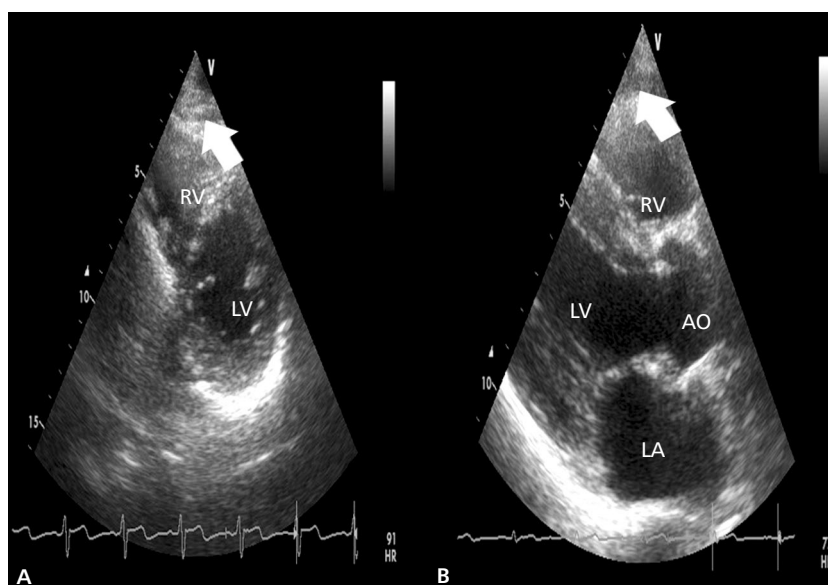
Arrows showing epicardial fat thickness measured by echocardiography in the parasternal short-axis (A) and long-axis (B) views; AO — aorta; LA — left atrium; LV — left ventricle; RV — right ventricle
